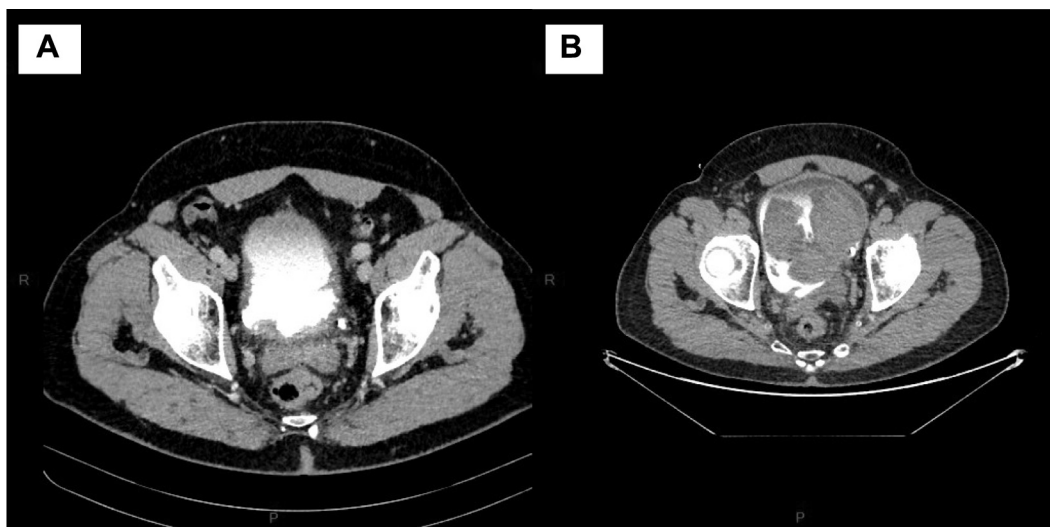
CT images show the rapid local progression of the tumor bladder. A: Day of diagnosis. B: 2 months after diagnosis.
